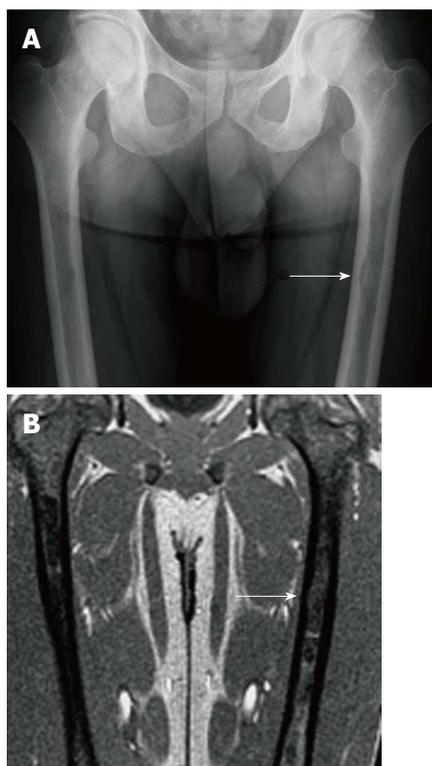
Endosteal scalloping. Frontal radiograph (A) of the femurs shows an area of rounded thinning of the medial cortex of the left femur (arrow). Coronal out of phase image of the femurs in the same patient (B) shows low signal intensity in that same area due to expansion of the medullary cavity due to infiltration. The thinning of the cortex is less apparent on magnetic resonance than on radiography.
